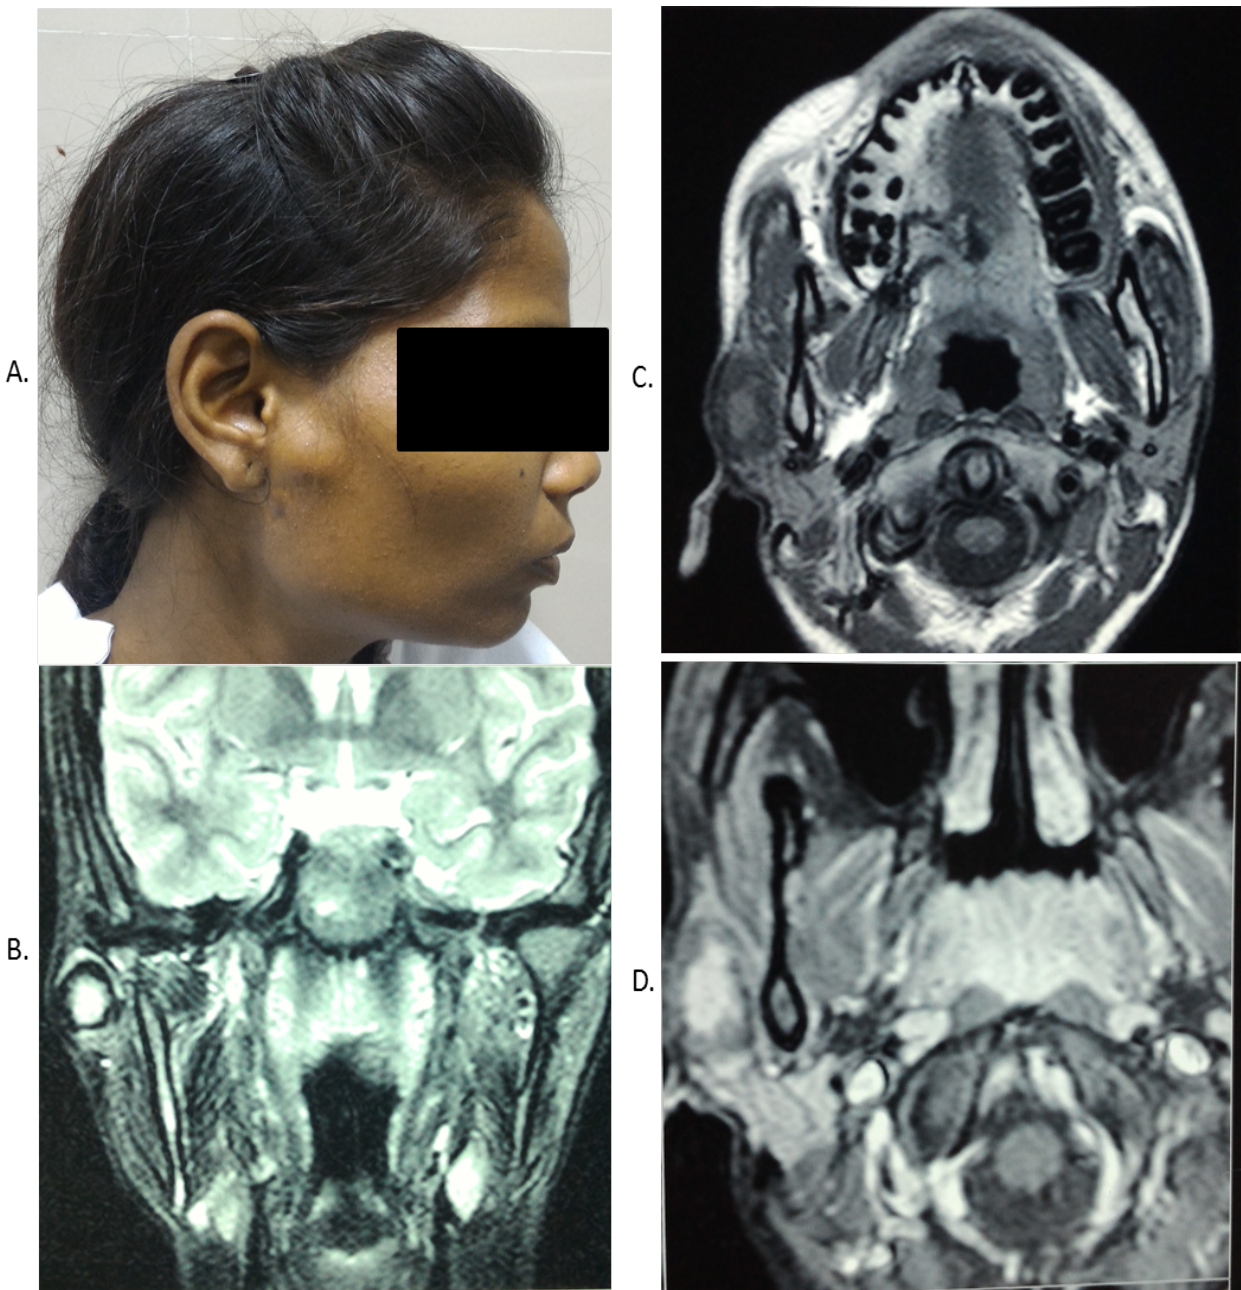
A. Right parotid swelling MR imaging shows well-defined lesion in superficial lobe of right parotid gland. B. Hyperintense on T1 with hypointense rim C. Hyperintense on T2 with hypointense rim D. Heterogeneous post-contrast enhancement
